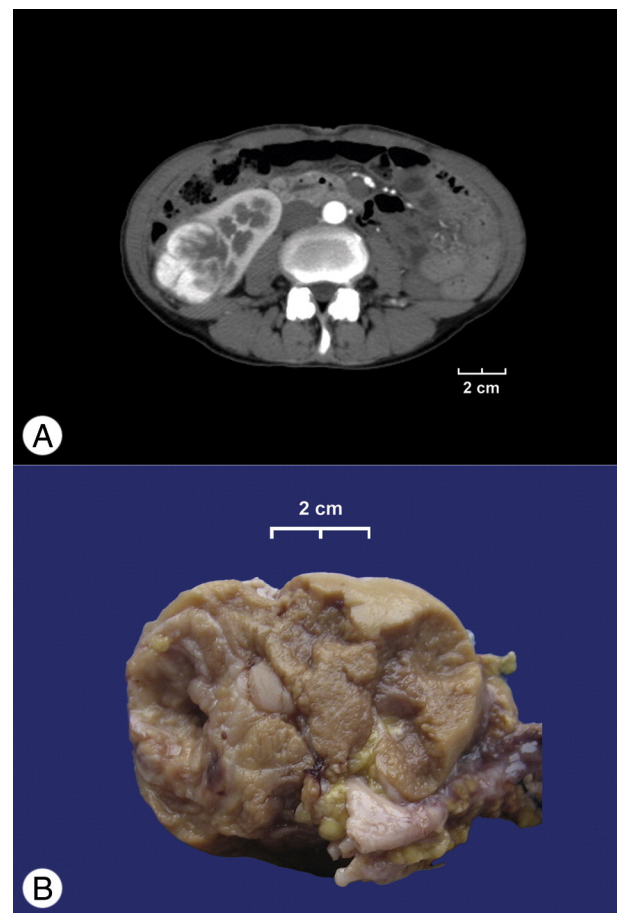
Renal hemangioblastoma. A, Abdominal computed tomography demonstrates a solid, lobulated, heterogeneously enhancing mass located in the lower pole of the right kidney. B, Gross appearance of the tumor shows a gray-to-brown solid mass with heterogeneous fibrotic areas.
